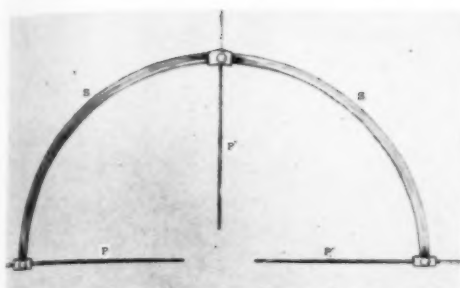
Instrument for interpretation of x-ray markings and for localization of foreign body.
